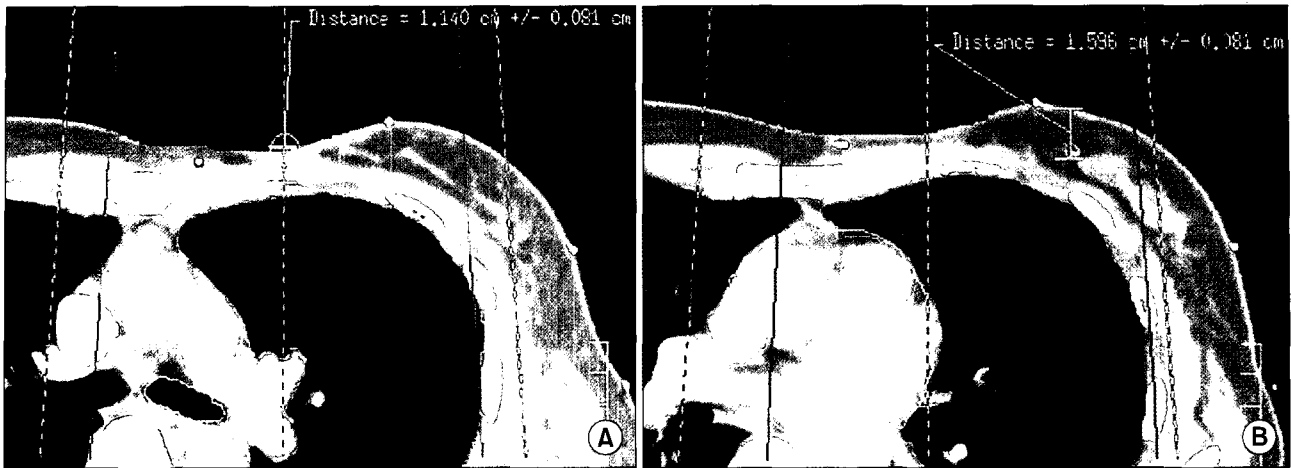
CT slices of patient 8 (A) through the center of the electron field showing the skin to chest wall distance (SCD), (B) showing the deepest clip distance.
